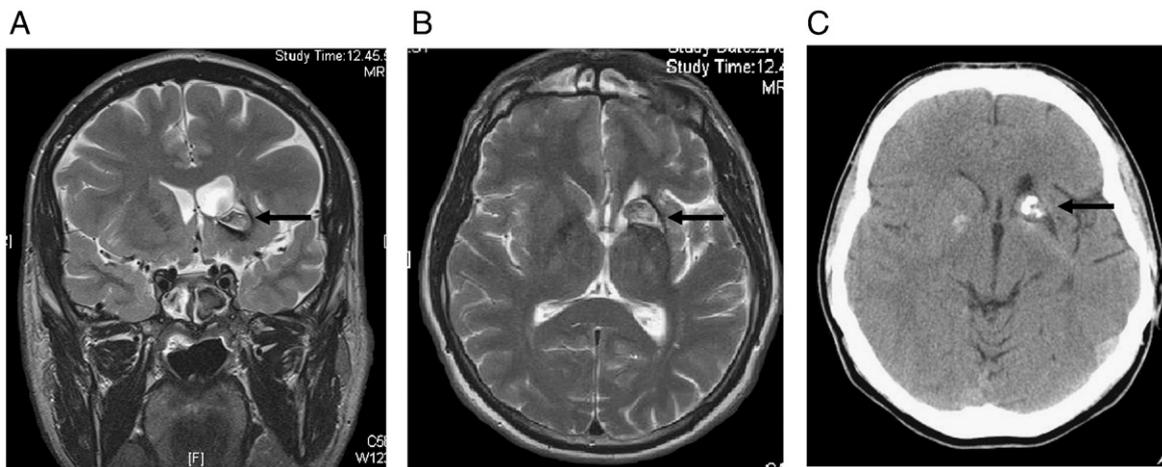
Follow up T2 MR images (A, coronal and B, axial planes) and CT image (C) showing calcification and haemosiderin debris in the left striatum nucleus (black arrow) with ventricular compensatory dilation.
